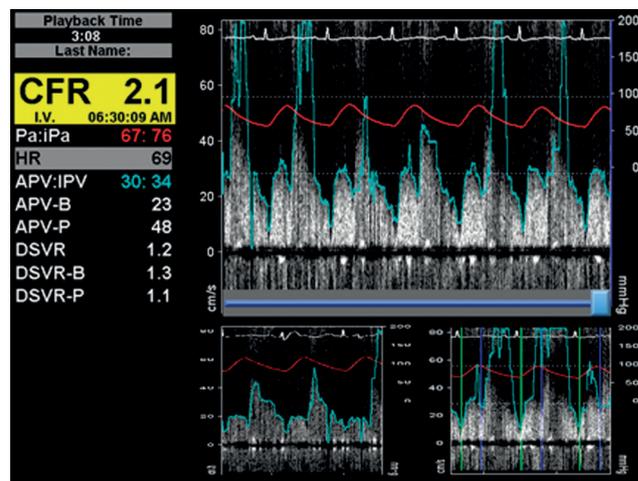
Measurement of the coronary flow reserve (CFR) by intracoronary Doppler ultrasound. The flow velocity signals are recorded at baseline (lower left) and maximal hyperaemia (lower right panel).
